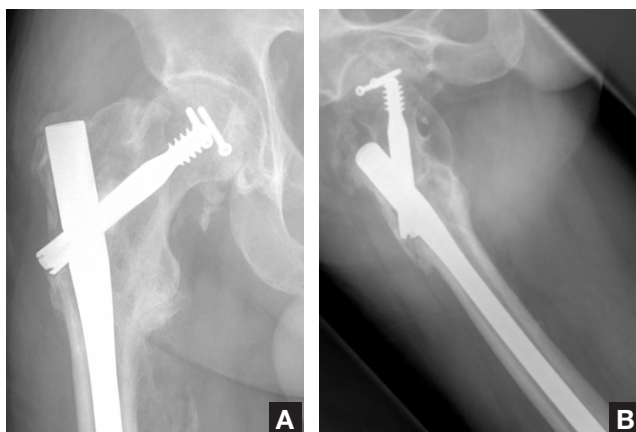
Final anteroposterior (A) and lateral (B) plain films obtained 7 months after trauma show healed fractures. Heterotopic ossification in the quadriceps muscles is also noted.
